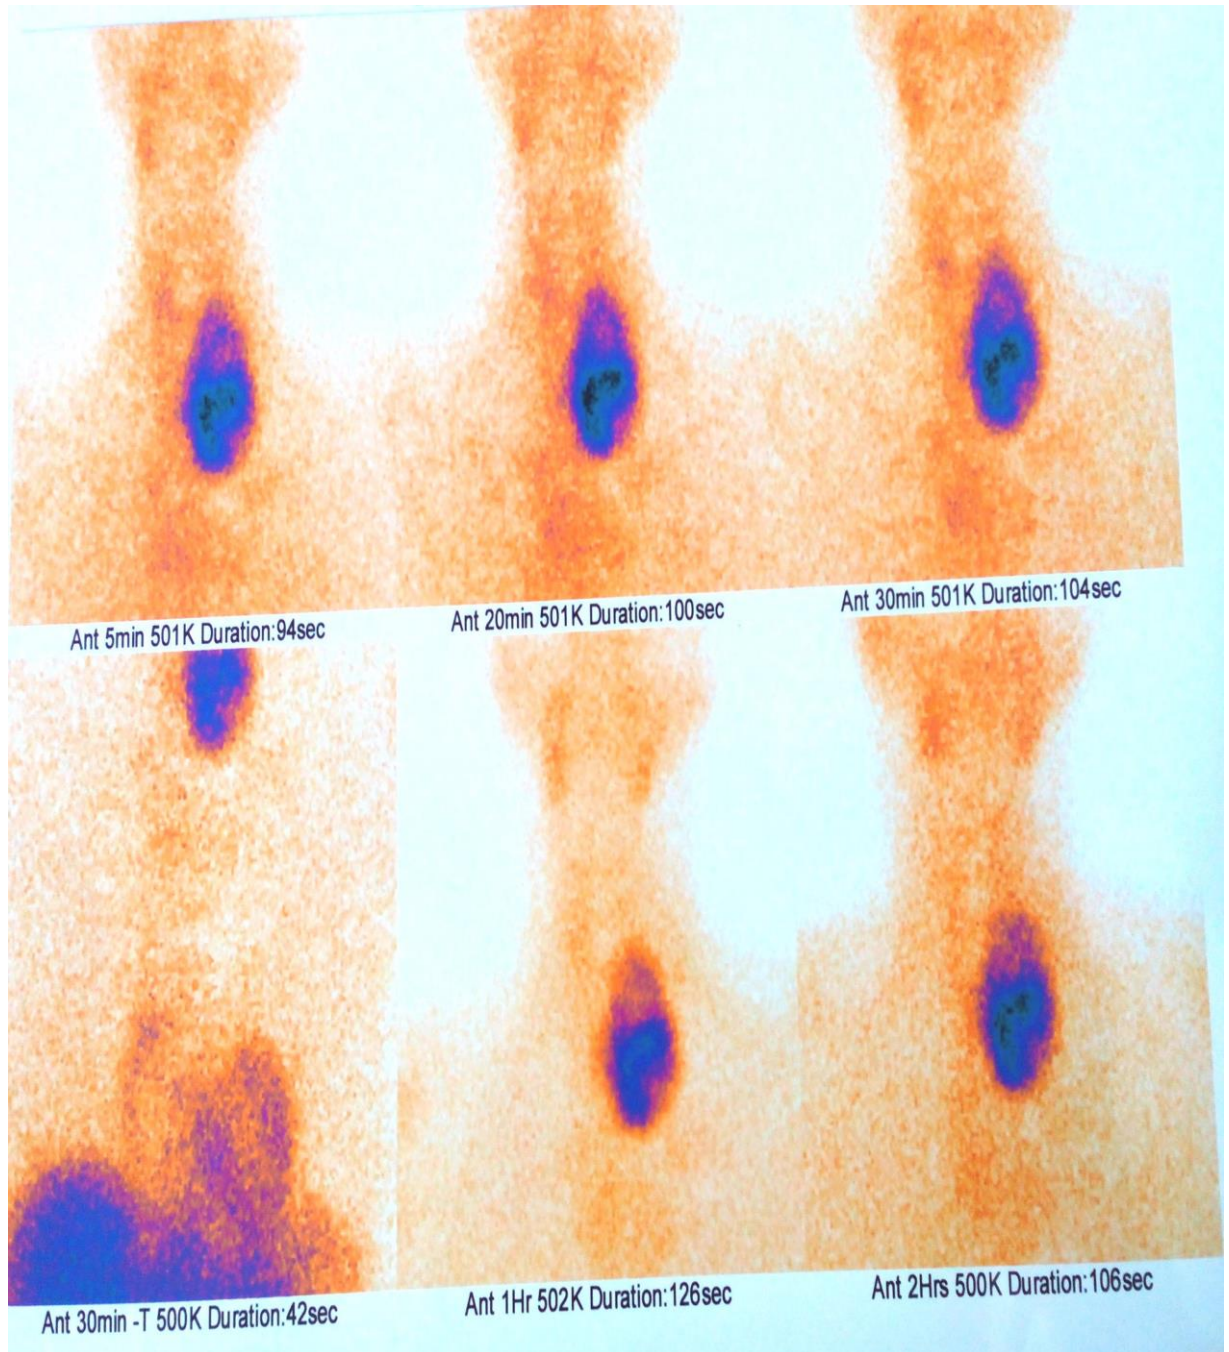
Legend: Metaiodobenzylguanidine scintigraphy(MIBG) scan showing increased uptake of radioactive tracer in left lower parathyroid gland.
